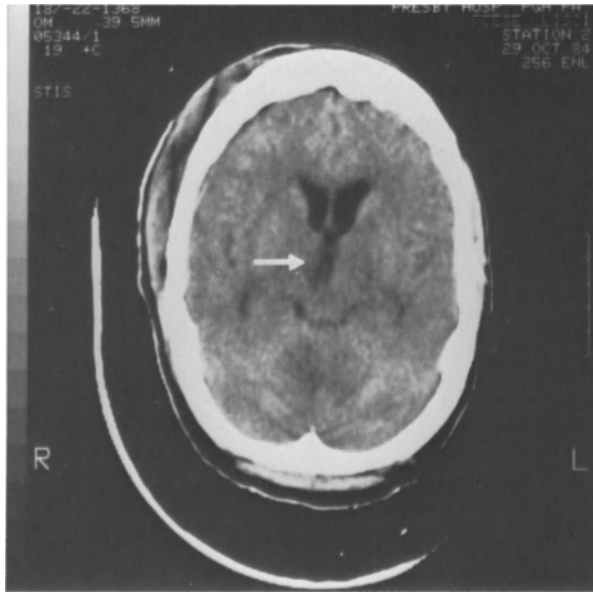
b. A CT study obtained 12 days later demonstrated a CT pattern of infarction only in the region where flows had been below  $10 \text{ cm}^3/100 \text{ g/minute}$
